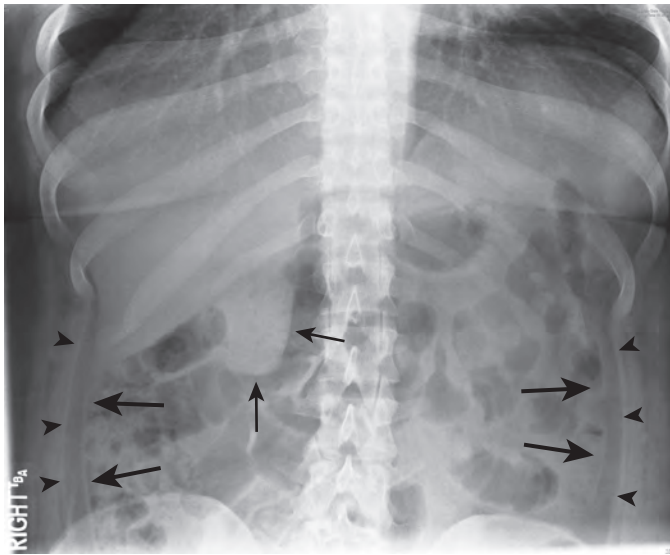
Paracolic gutters and lateral conal fascia. Coned-down view from supine abdominal radiograph shows the left and right paracolic gutters between the transversalis fascia (arrowheads) and lateral conal fascia (large arrows). Small arrows denote the gallbladder.
